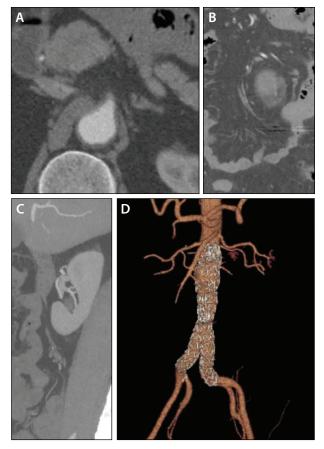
Postoperative CTA at 1-month follow-up showing no type I endoleak (A-D).
